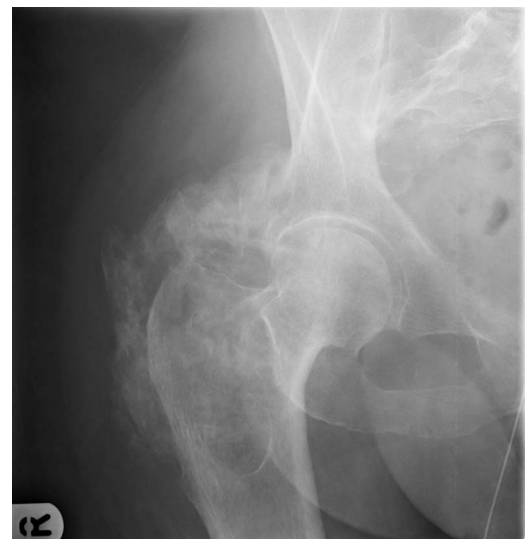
Plain film radiograph demonstrates diffuse calcification surrounding the right hip. The joint itself is preserved.
